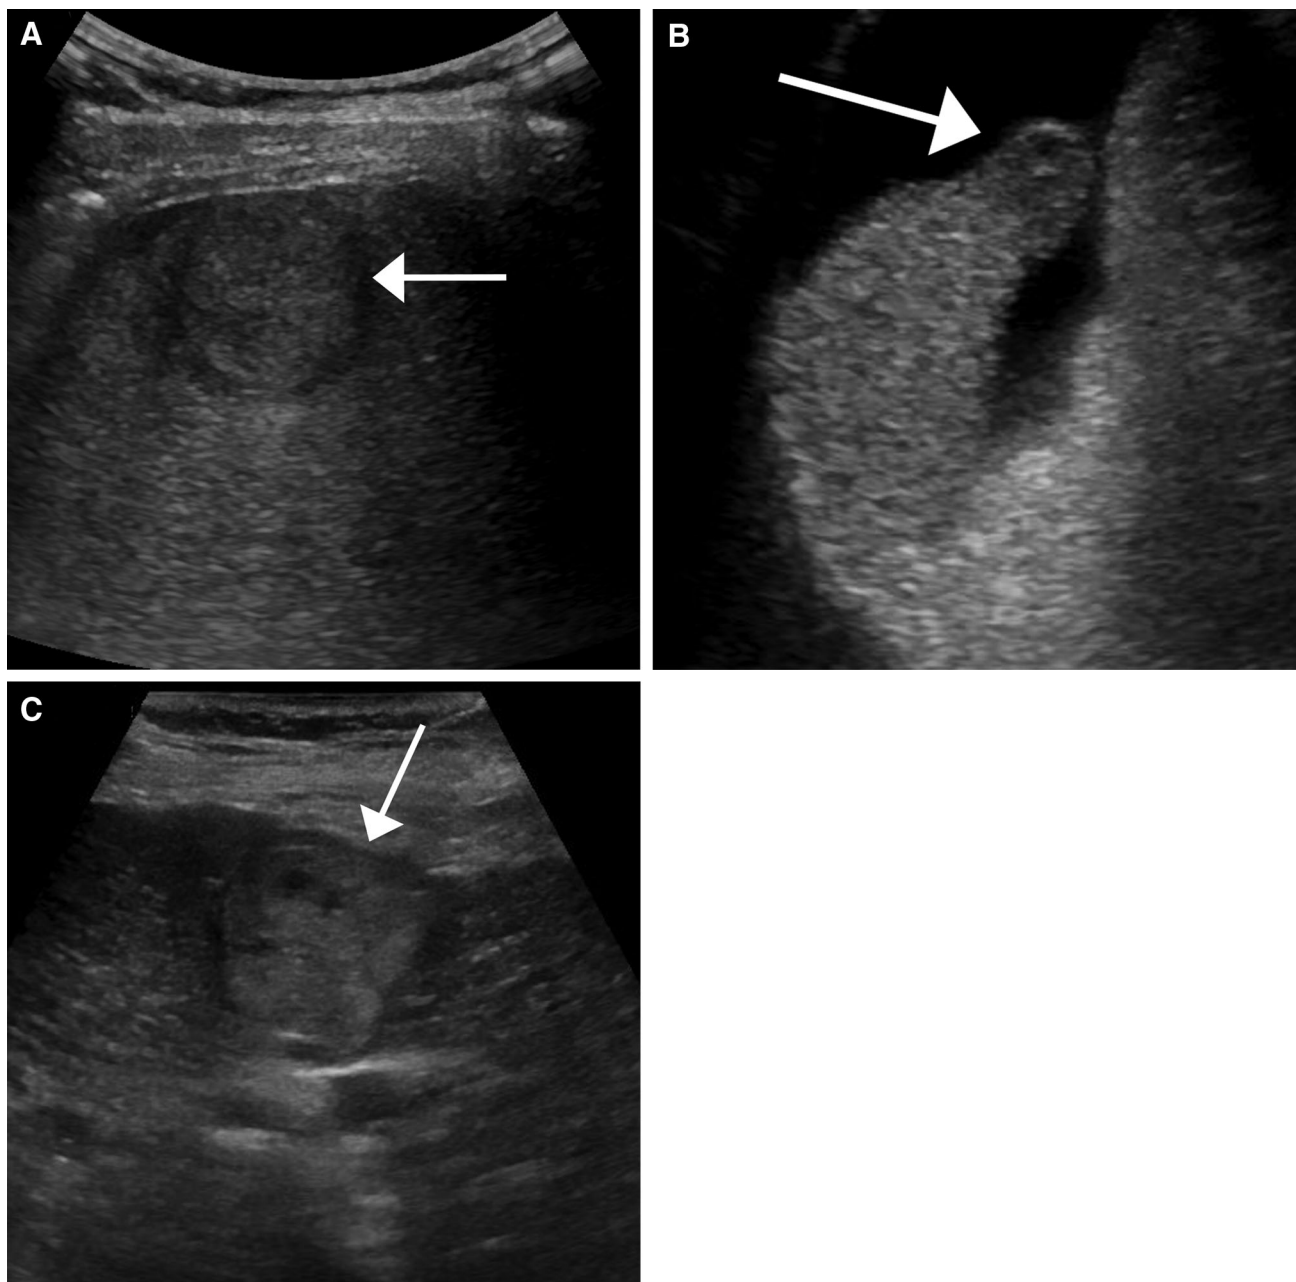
Three cases of HCC (*arrows*) are shown on grayscale ultrasound images with different echogenicities. Because of potentially variable appearance of HCC, echogenicity of focal liver observation does not affect LI-RADS category
